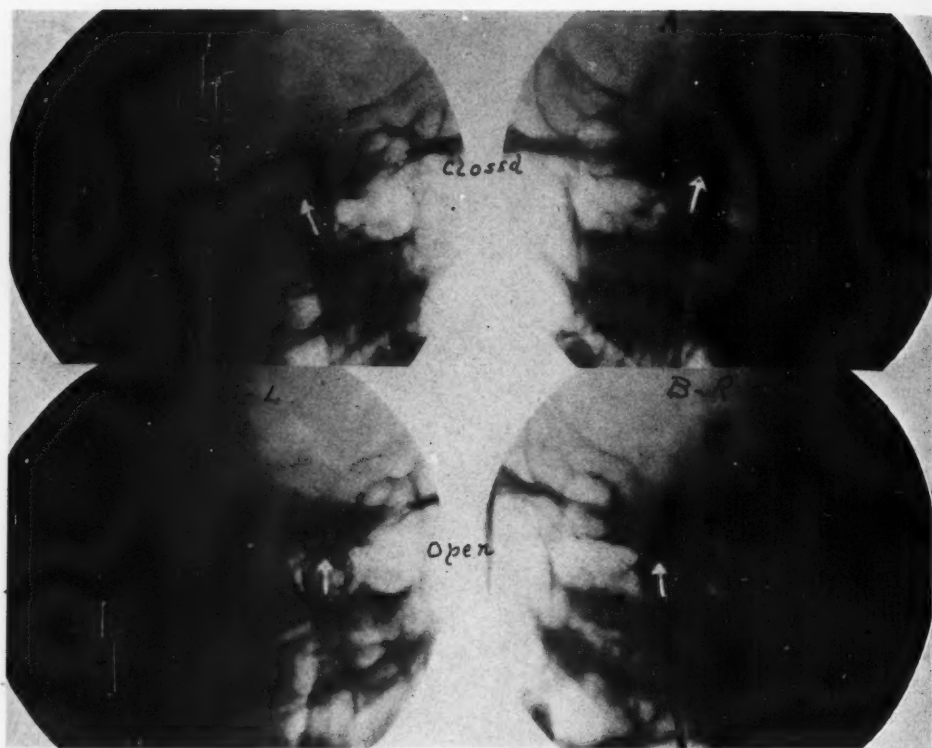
Erosion of the meniscus with marked joint or condylar changes. Case 3, Mr. O., aged 63. *Clinical Symptomatology* (with pain symptoms).—Tinnitus and impaired hearing, involving right, then left, side, for ten years—exaggerated when new dental plates were acquired one year ago. Burning along right side of tongue during above period, with marked dryness of mouth. *Roentgenological Findings*.—In the closed position, the condyles rest flush against the tubercle, showing evidence of perforation of the meniscus; erosion and flattening of the anterior surface of the condyles—more marked on the left; open position shows slight restriction of movement of condyles. *Treatment*.—Dental plates replaced, increasing vertical molar dimension slightly, and closing incisors, thus moving condyles straight backward in their closed position. *A-L*, Closed position, left mandibular joint; *A-R*, Closed right mandibular joint; *B-L*, Open left mandibular joint; *B-R*, Open right mandibular joint.
